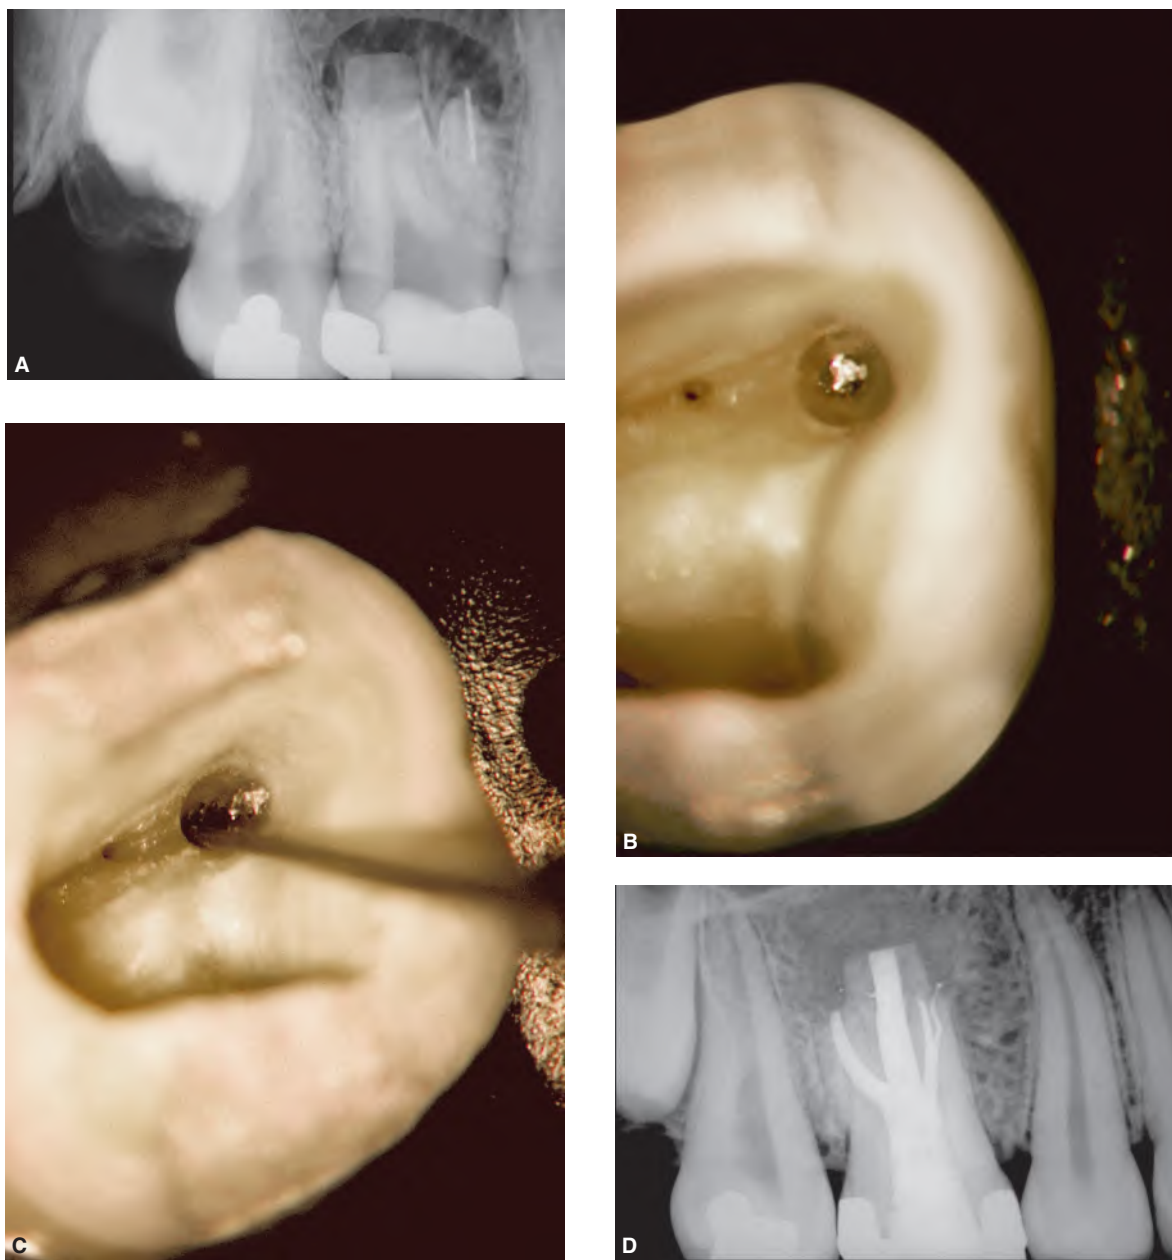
A. An off-angled radiograph of a maxillary first molar reveals a separated instrument, a possible MB-2 system and resected roots from a previous surgical procedure. B. Photograph showing access, an MB-2 orifice, the separated instrument, and the circumferential staging platform to facilitate ultrasonics. C. Documentation reveals an ultrasonic instrument has loosened and coronally displaced the separated instrument. D. A recall radiograph showing evidence of initial healing. Barriers were utilized in the DB and P canals to facilitate control and encourage three-dimensional filling.
